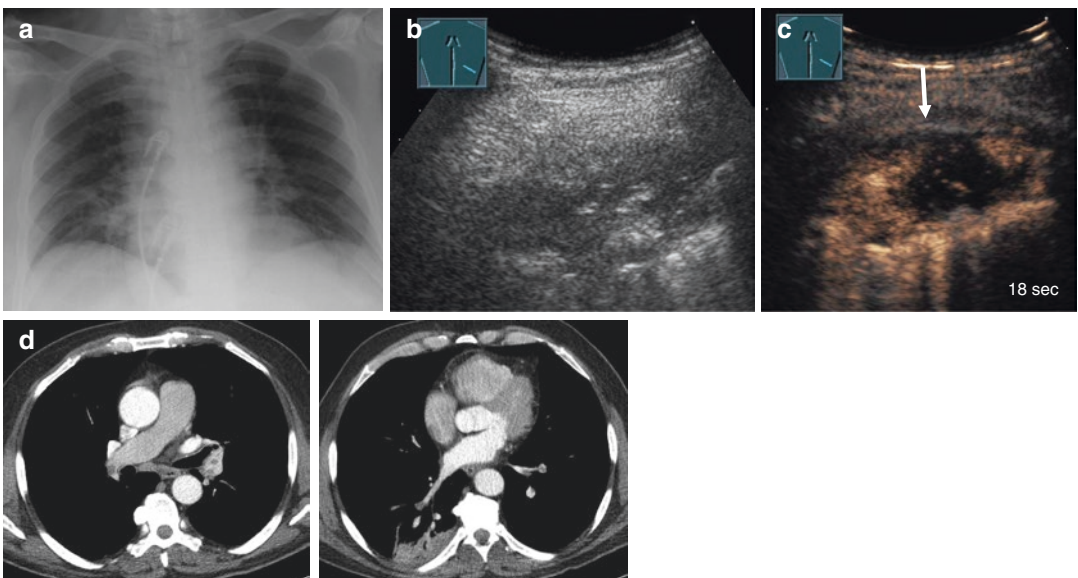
Patient with clinical diagnosis of pneumonia and the corresponding lung infiltration on X-ray examination (a); B-mode imaging presents an inhomogeneous lung consolidation with multiple round hypoechoic lesions within the lung tissue (b); CEUS shows a marked enhancement of the lesion with multiple non-enhanced round areas suggesting *lung abscesses* (c)
